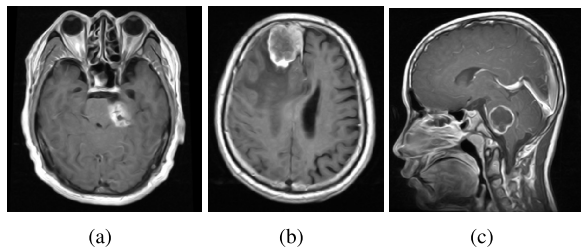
Adaptive wiener filtering output of Brain MRI images of three planes axial plane, sagittal plane and coronal plane.
